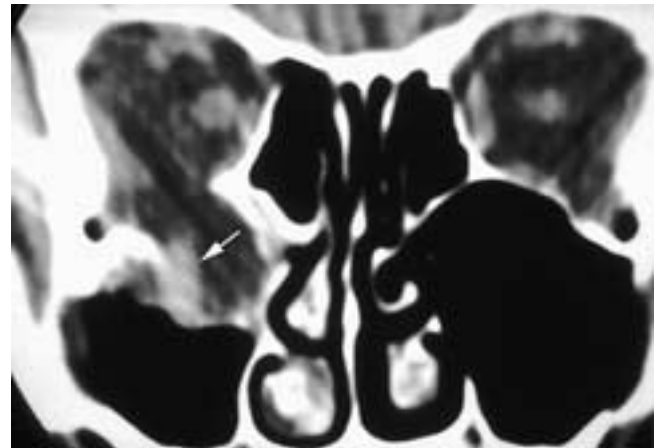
Coronal CT scan shows a large right orbital floor blow-out fracture. The inferior rectus muscle (*arrow*) is depressed into the fracture. This muscle was entrapped on the lateral fracture margin.
